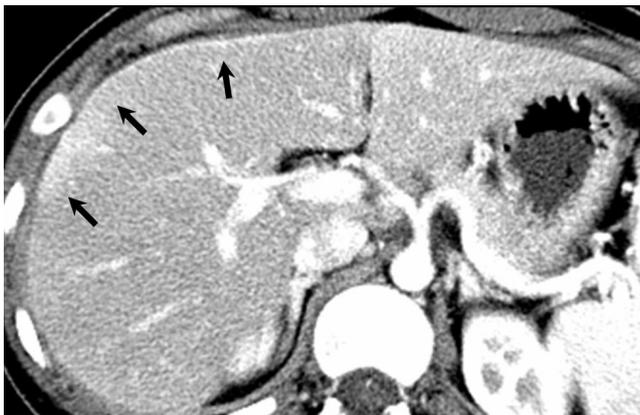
A 21-year-old female with Fitz-Hugh-Curtis syndrome. On arterial phase CT scan, diffuse hepatic capsular enhancement (arrows) is seen in anterolateral surface of liver.
